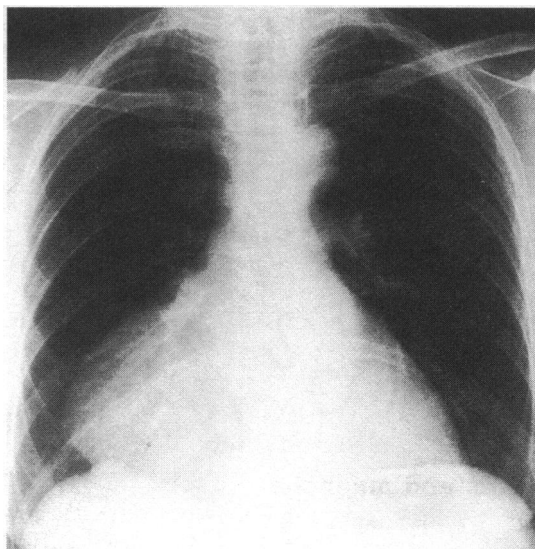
P-A chest X-ray showing an apparently massive cardiac shadow
